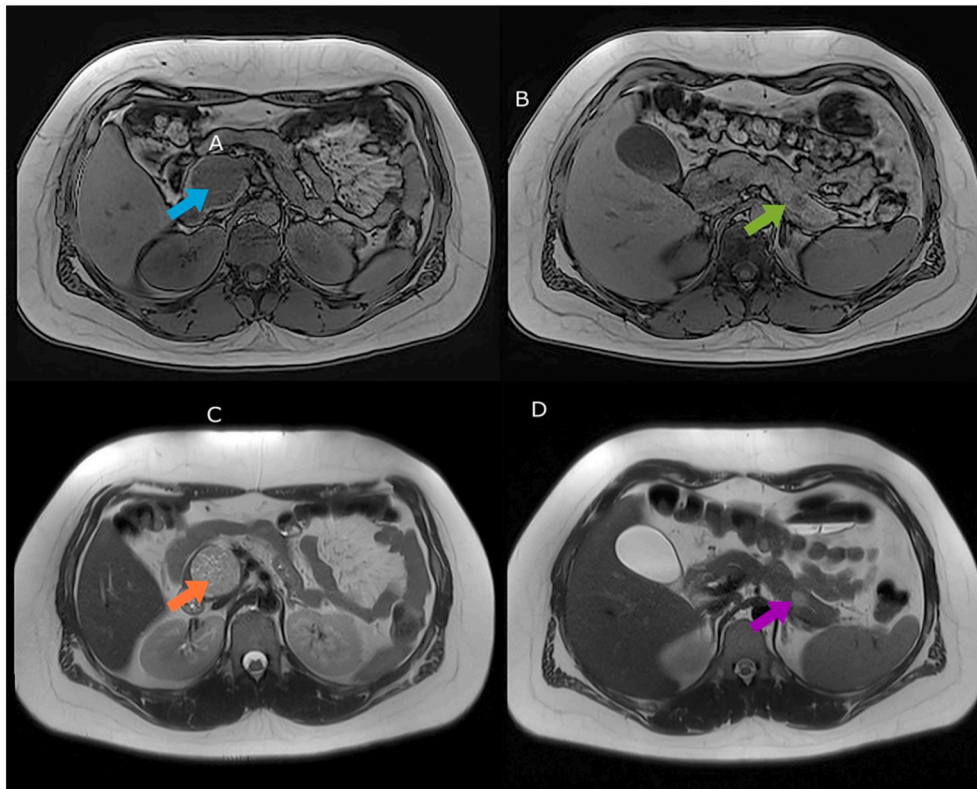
A) and B) MRI sequence T1, out of phase. Blue and green arrows indicate pancreatic head and tail lesions with a slightly hypointense signal on T1. C) and D) MRI sequence T2, orange and fuchsia arrows indicate lesions in the head and tail of the pancreas.
